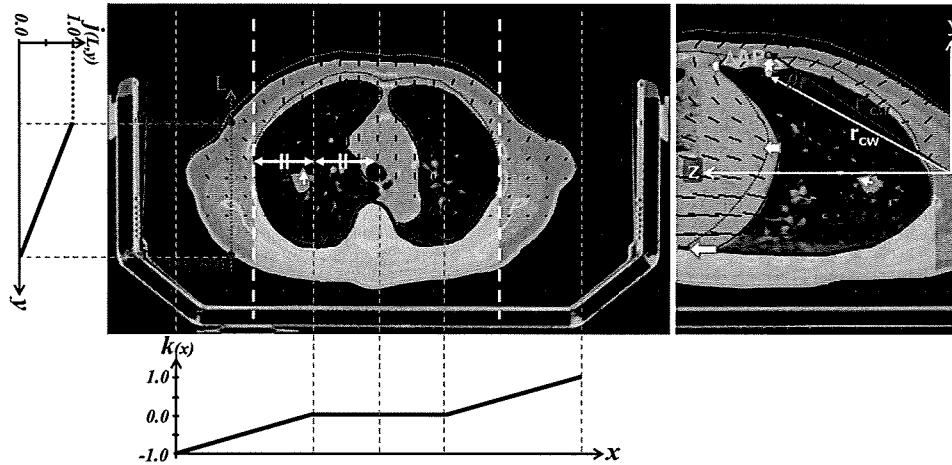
Computing the transformation map required to create 3D-CT images for an arbitrary breathing phase. For points outside of the thoracic cage, transformation vectors in the anterior thoracic wall were determined by sagittal rotation (θ) and lateral linear scaling [$k(x)$]. The rotational axis was set at the intersection of the horizontal plane at the lung apex and the midcoronal plane. $\mathbf{r}_{CW}, \mathbf{r}'_{CW}$ indicates the position of the observation point in the anterior chest wall in the original CT phase and selected phase i . \mathbf{r}'_{CW} was calculated from the AP motion of the chest wall (ΔAP), as observed via fluoroscopic imaging. The coefficient function $k(x)$ has a zero band, which is set to half the size of the thoracic cage in the middle to avoid scaling of sternum. The posterior thoracic wall (shaded area around thoracic vertebra) and body surface in contact with immobilization device (shown as a thick green line) were assumed to be fixed. Also, vectors in the side thoracic wall were linearly interpolated [$j(L, y)$] from the vectors of points on the ventral and dorsal body surfaces. Inside the thoracic cage, transformation vectors were determined by incorporating the vector element of tumor motion into the vector posed by scaling in each direction.
